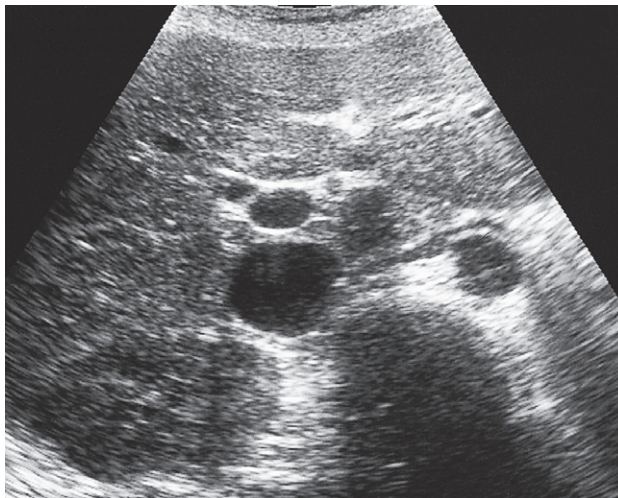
Ultrasound of normal liver. Transverse scan across the porta hepatis. Ao, aorta; IVC, inferior vena cava; PV, portal vein.
